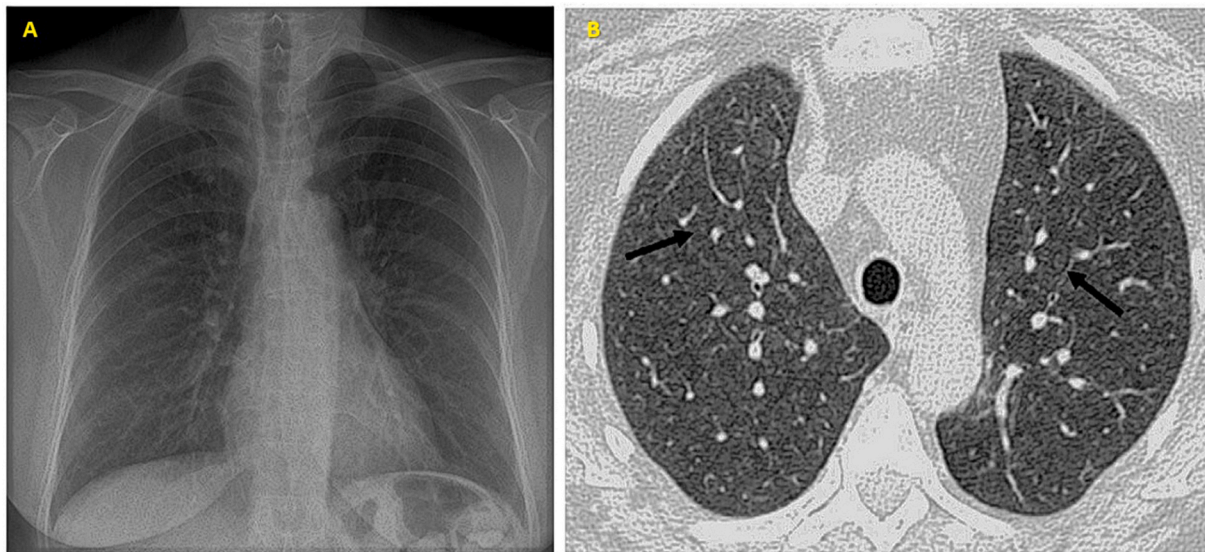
(A) Patient's thoracic x-ray and CT scan (B) showing upper lobe centrilobular ground-glass pattern (arrows).
